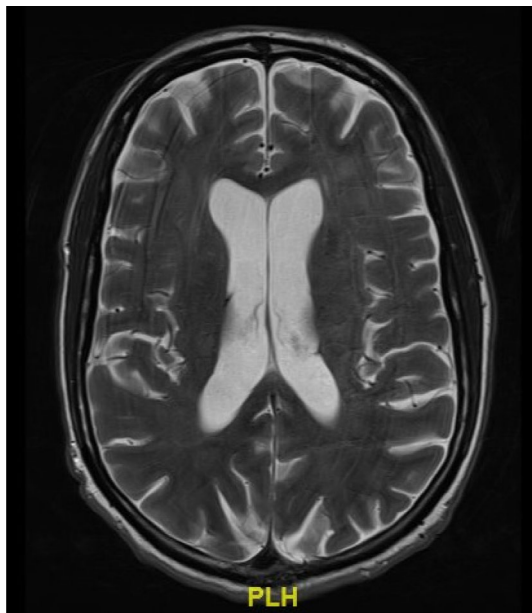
Brain MRI (T2 imaging) showed diffuse cortical atrophy compatible with HIV-encephalopathy.
